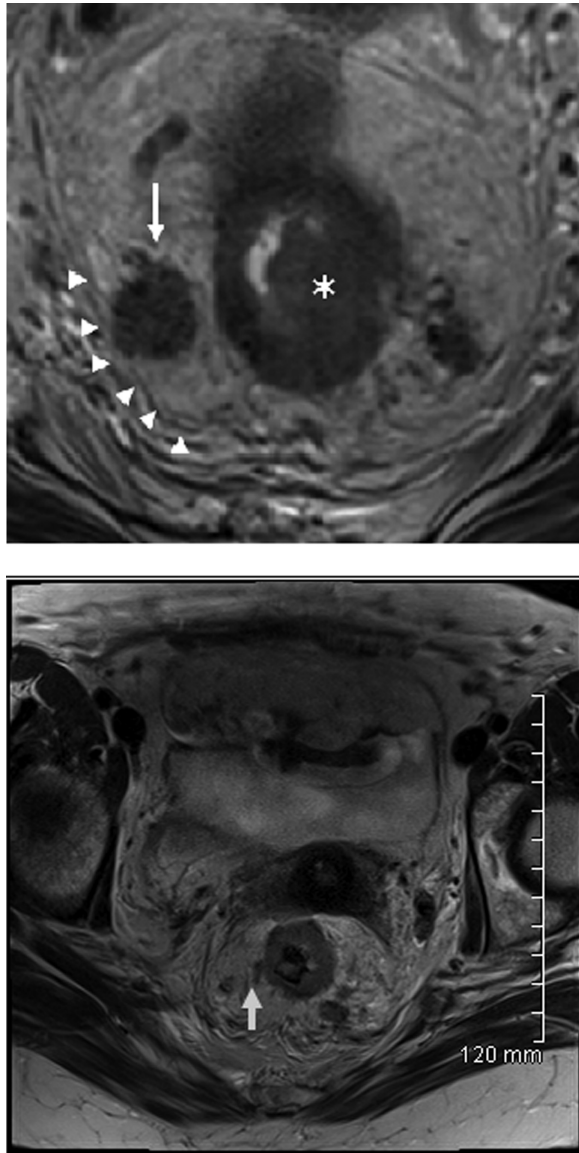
High-Resolution Magnetic Resonance Imaging of Rectal Cancer Used For Staging. (Top) An axial T2-weighted, non-fat-saturated image demonstrating a rectal tumor identified invading the muscularis propria (*). There is an adjacent enlarged heterogenous lymph node (arrow) in contact with the mesorectal fascia (arrow heads). Incidental note is made of another heterogenous lymph node to the left of the rectum. (Bottom) Vascular invasion in the linear area of an abnormal T2 signal extending from the tumor margin (arrow).
